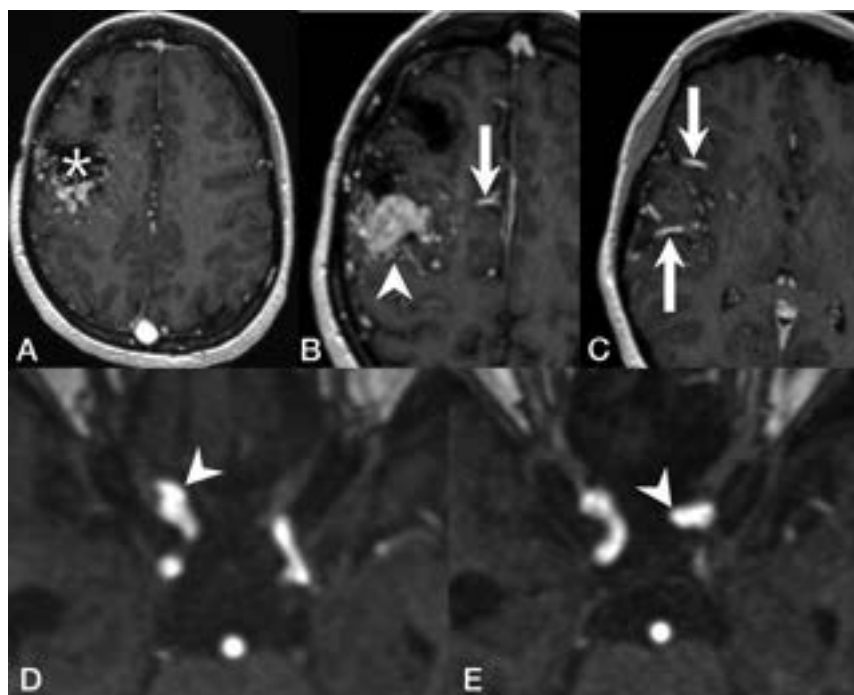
Representative images of a patient with HHT with flow-related cerebral aneurysms. T1 contrast-enhanced MR images demonstrate a Spetzler-Martin grade III right frontal AVM with a nidus size of 4 cm (*A*, asterisk) and venous varices (*B*, arrowhead), supplied by several dilated arterial feeders from the right anterior cerebral arteries (*B*, arrow) and the right middle cerebral arteries (*C*, arrow). MRA demonstrates a clinoid segment aneurysm of the right ICA (*D*, arrowhead) and another aneurysm arising from the ophthalmic segment of the left ICA (*E*, arrowhead).
